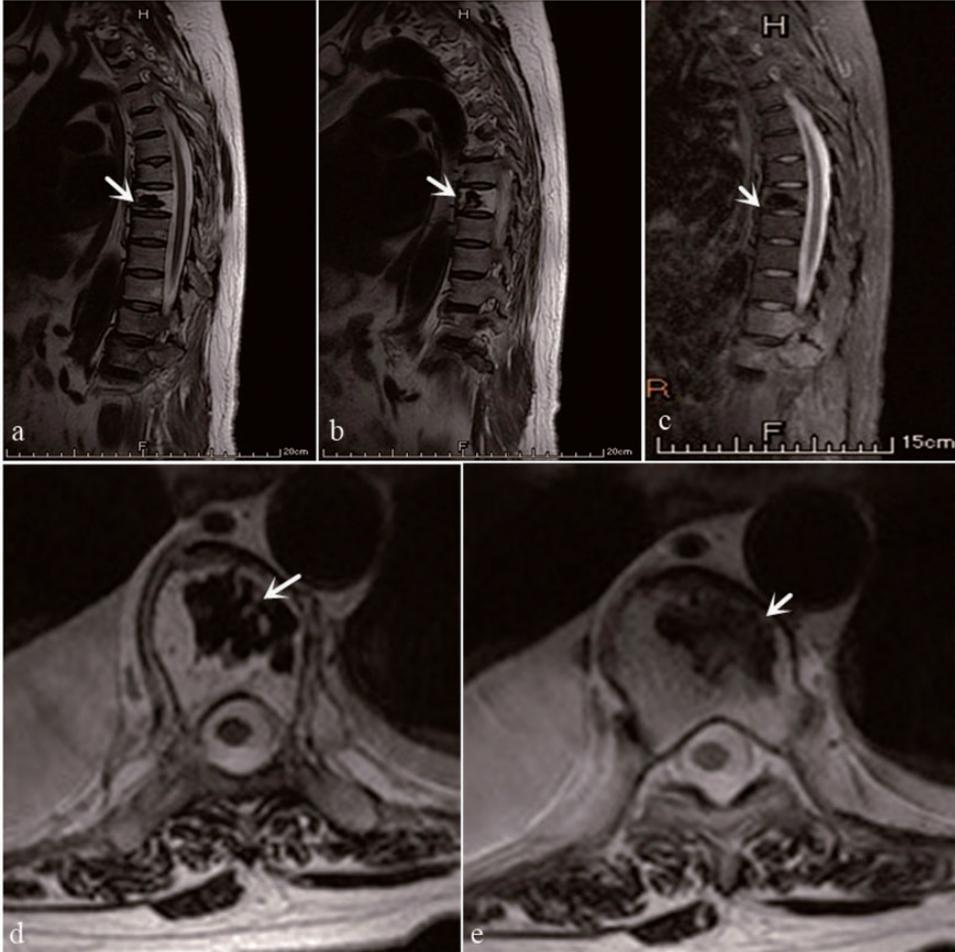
Magnetic resonance images (MRI). a, b, d and e: High signal intensity (hemangioma) combined with low signal intensity (bone island) in T1-weighted/T2-weighted (T1WI\T2WI) images; c: Most of T7 shows a low signal intensity (bone island) in this T2WI fat saturation image, whereas bone metastases show a high signal.
